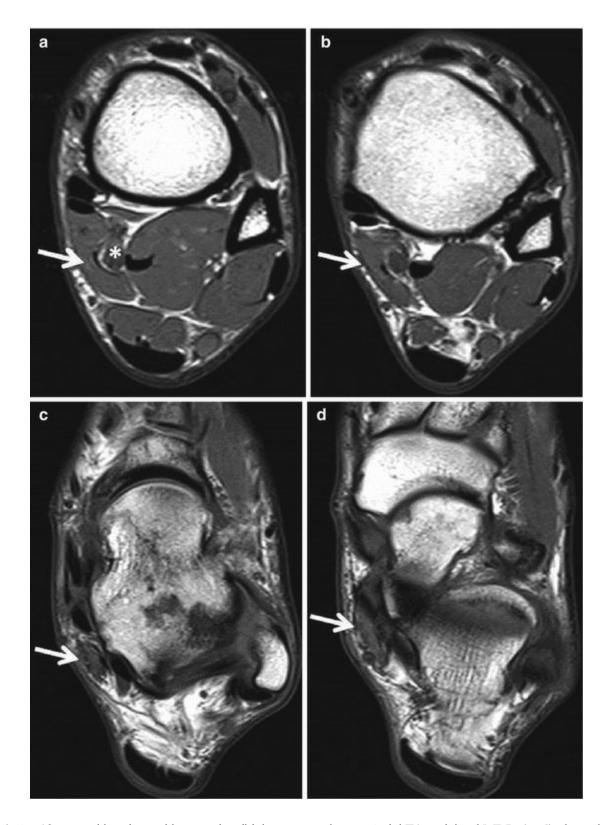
An 18-year-old patient with posterior tibial nerve syndrome. Axial T1-weighted MRIs (a–d) show the presence of a flexor digitorum accessorius longus (FDAL) muscle (*arrow*), embedding the posterior tibial nerve and reaching the FDL distally. Intraneural cyst of the posterior tibial nerve is visible (*asterisk*)
